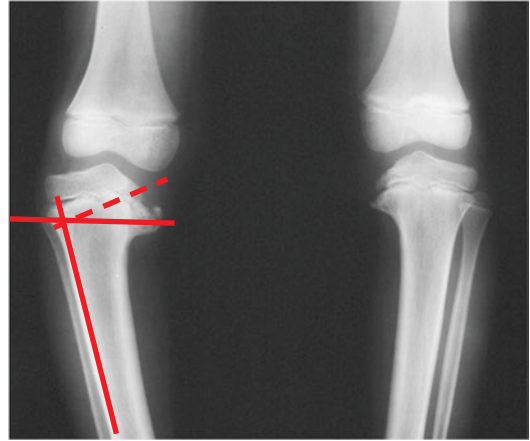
Anteroposterior X-rays of both legs. In this case the metadiaphyseal angle is 20°, indicating Blount disease
